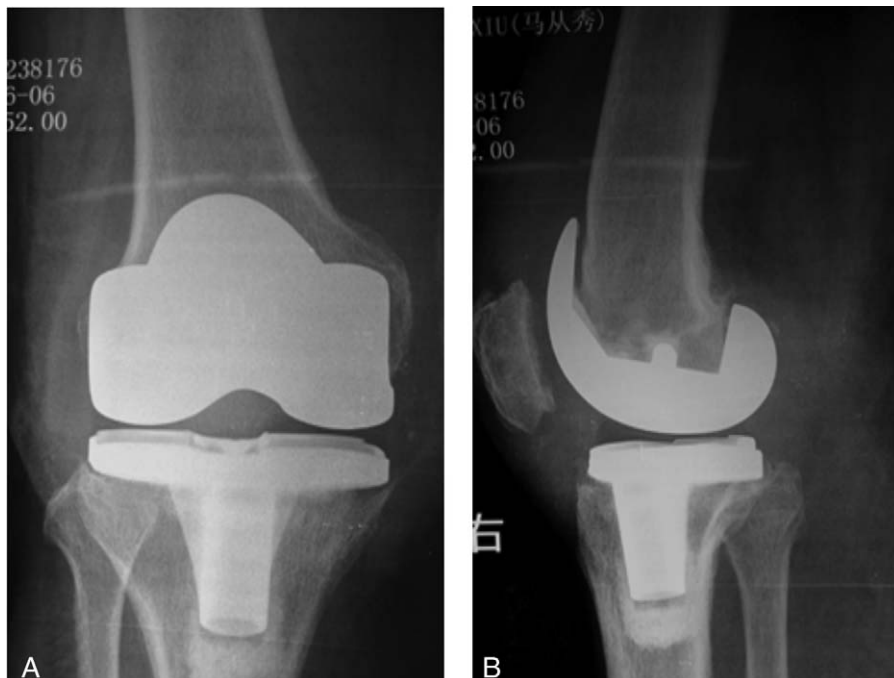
The implant is fixed well and the position is appropriate. (A) Anteroposterior radiograph. (B) Lateral radiograph.
